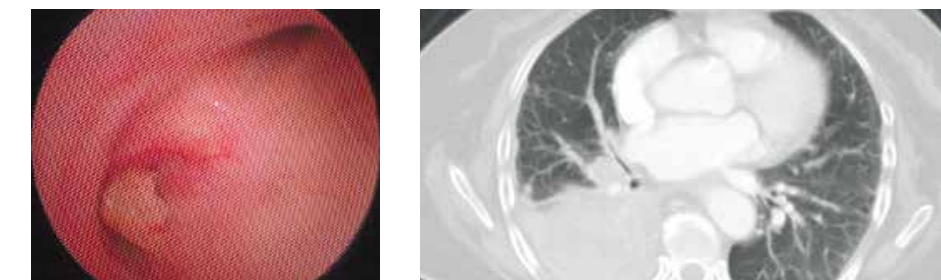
Bronchoscopy and CT chest pre-PHOTOFRIN® (porfimer sodium) for Injection treatment.
